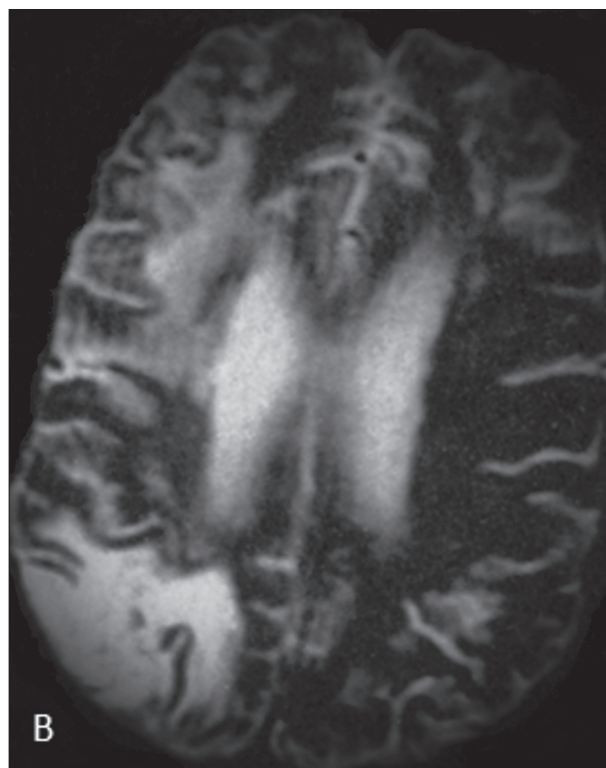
Control axial spin-echo MR image of endocranium shows two hyperintense signal changes in the right cortical gray matter and subcortical white matter (old infarcts). There were no new cerebrovascular accidents.
